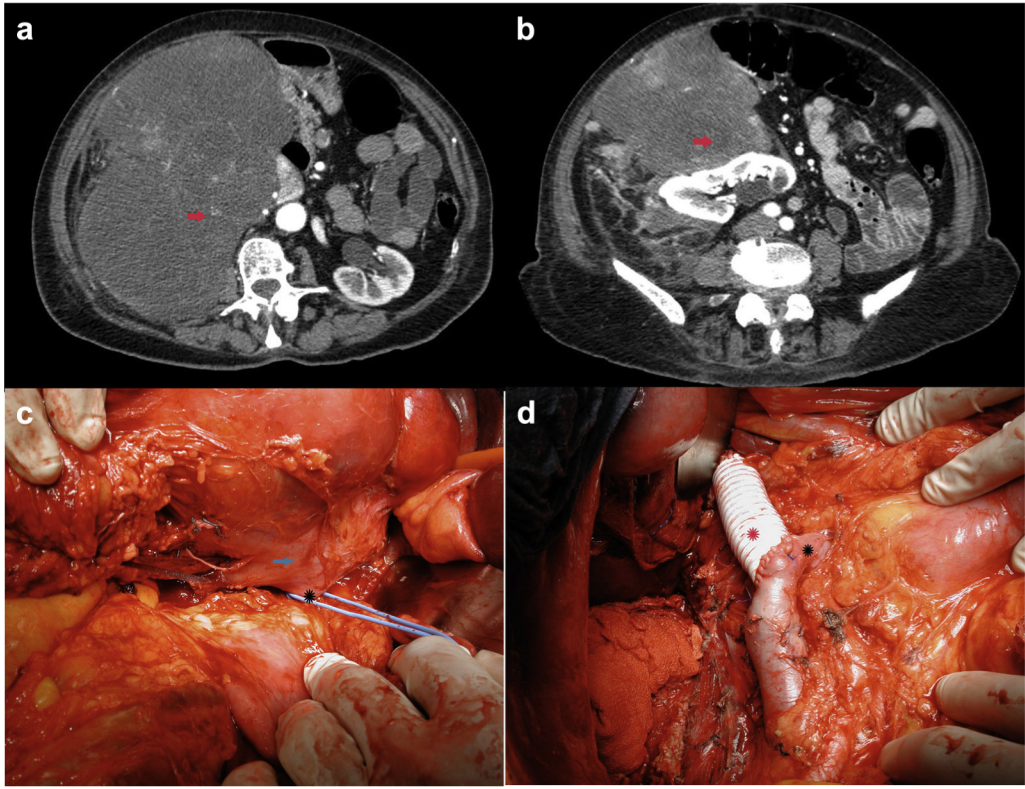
a and b, Abdominal computed tomography (CT) scan shows a voluminous retroperitoneal soft tissue sarcoma (RSTS; red arrow) located in the right compartment encasing the inferior vena cava. c, Intraoperative view shows the large RSTS encasing the inferior vena cava (green arrow). d, Intraoperative view shows the resected inferior vena cava replaced by a prosthetic graft (red star) and the preservation of the left renal vein (black star).
